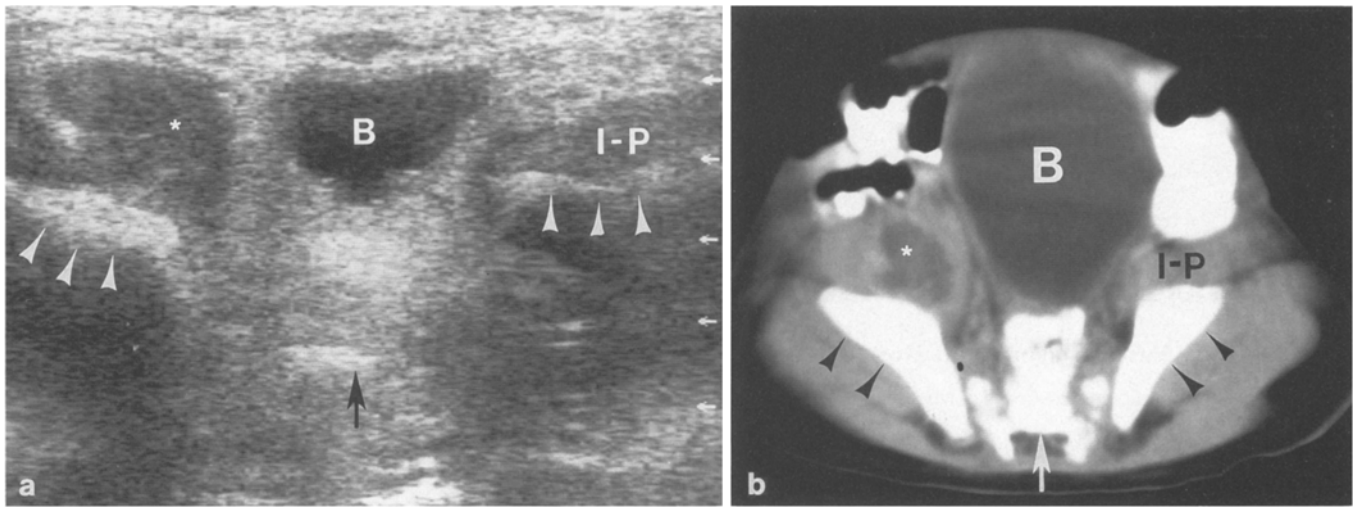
a Transverse (axial) image from a pelvic sonogram in case 2 reveals enlargement of the ilio-psoas muscle on the right (*). The left ilio-psoas muscle is normal (*I-P*). (*B*, bladder; *arrowheads*, iliac bone; *arrow*, sacrum). b Contrast-enhanced axial CT scan in case 2 at
